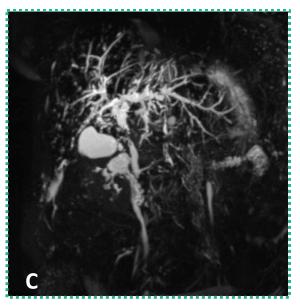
Contrast-enhanced CT (A, portal phase; B, delayed phase), MRCP (C) - ISC Marked circumferential symmetric wall thickening of the bile ducts, with smooth out.
